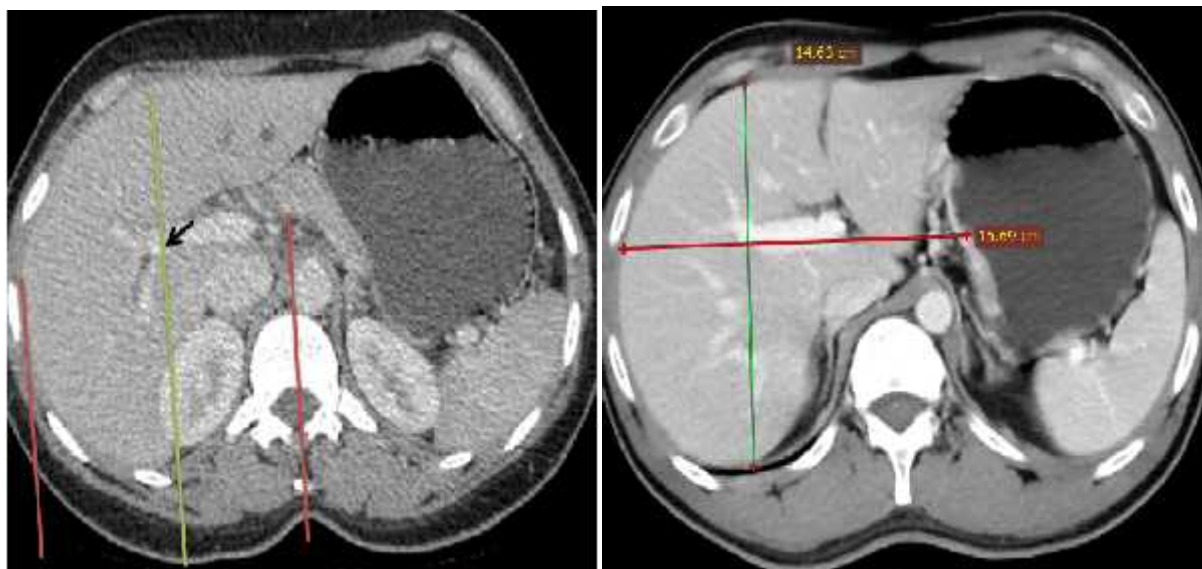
(left) axial CT scan of 35 years old woman shows a mid-hepatic point (black arrow) halfway between the mid vertebra and right lateral margin of the liver (red lines). Figure 2(right): showing the linear dimensions of the liver: Maximum transverse dimension (red) is the maximum measurement from the right to left margins of the liver. Mid hepatic point AP (MHP AP) measurement was taken at the level of the midhepatic point from anterior to posterior margin of the liver (green)
